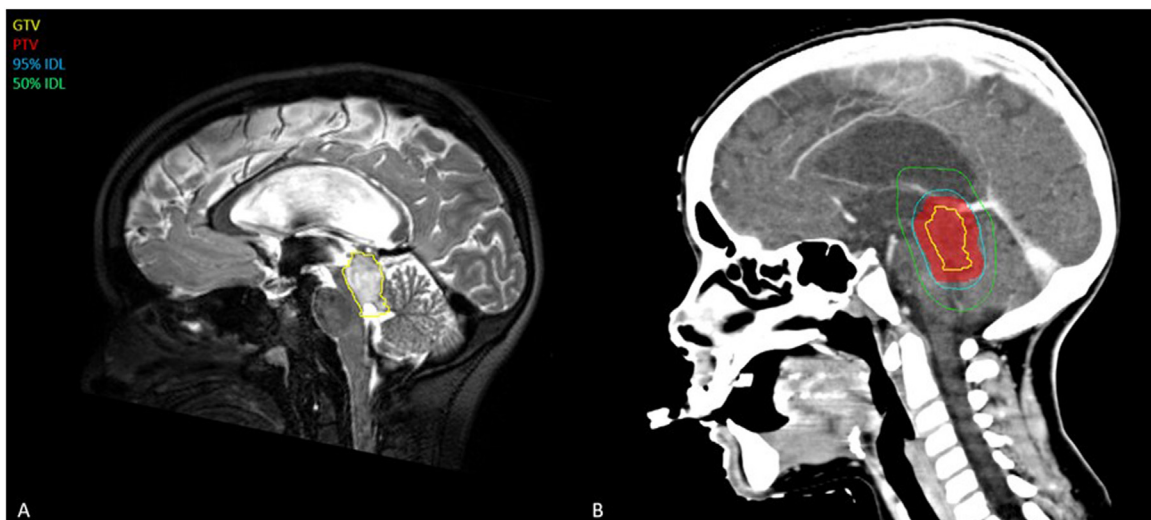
(A) Tumor delineated on the T2 magnetic resonance imaging (yellow = gross tumor volume). (B) Dose distribution of volumetric modulated arc therapy radiation therapy (yellow = gross tumor volume; red = planning target volume; blue = 95% isodose line; green = 50% isodose line).
